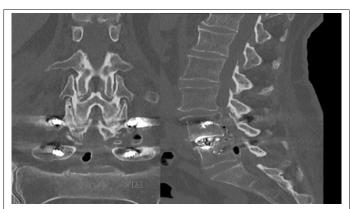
A postoperative sagittal and coronal reconstructed computed tomography (40 days post-op) image reveals an encapsulated EG. The collection was compressing the thecal sac and the left L5 nerveroot. The trans pedicle screw instrumentation at L4–L5 and the TLIF L4/L5 cage are also visible.
